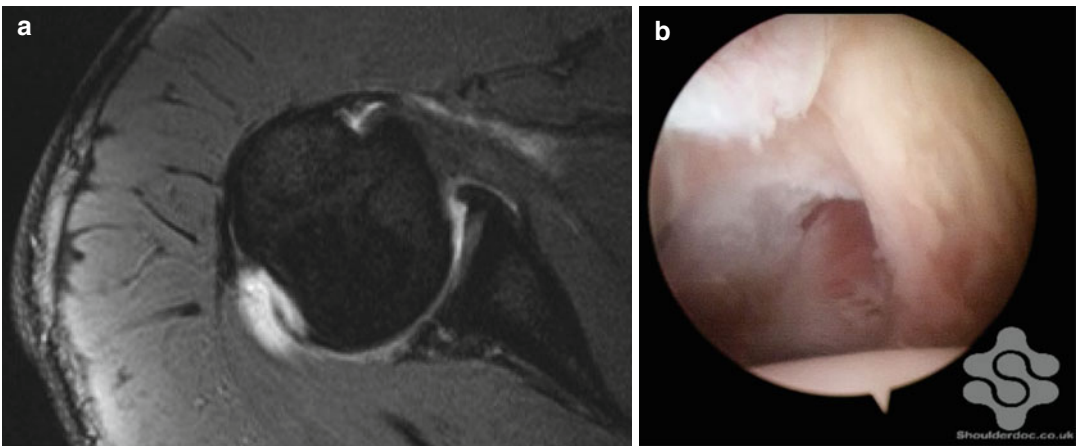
Reverse humeral avulsion of the glenohumeral ligament (RHAGL) on MRI arthrogram (a) and arthroscopy (b)
